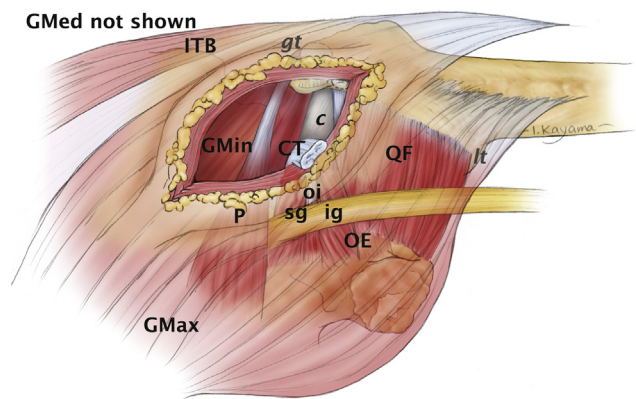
Preferred tendon release. In the preferred version of the Direct Posterior[™] approach, after incising the gluteus maximus fascia, the fibers of the muscle are carefully teased apart. At a point approximately 1 cm distal to the tip of the greater trochanter, the conjoined tendon can almost always be palpated. Overlying fat is removed using electrocautery and suction. The tendon can then be visualized as it courses beneath the posterior edge of the greater trochanter. This is distinct from the piriformis, which inserts at the tip of the greater trochanter. The CT is released beneath the edge of the trochanter as close to its insertion as possible. In most instances, all remaining external hip rotators and the ITB can be spared [33]. ITB—iliotibial band, GMax—gluteus maximus, GMed—gluteus medius, GMin—gluteus minimus, CT—conjoined tendon, P—piriformis, sg—superior gemellus, oi—obturator internus, ig—inferior gemellus, OE—obturator externus, QF—quadratus femoris, gt—greater trochanter, It—lesser trochanter, c—capsule. (c) Brad L. Penenberg
